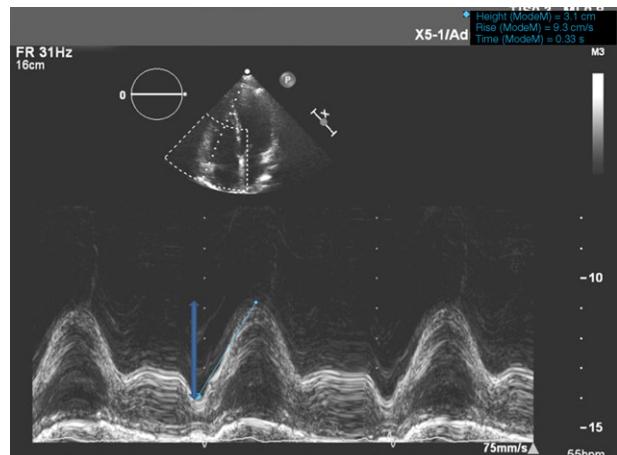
Standard technique for measuring tricuspid annular plane systolic excursion using one-dimensional mode echocardiography.
